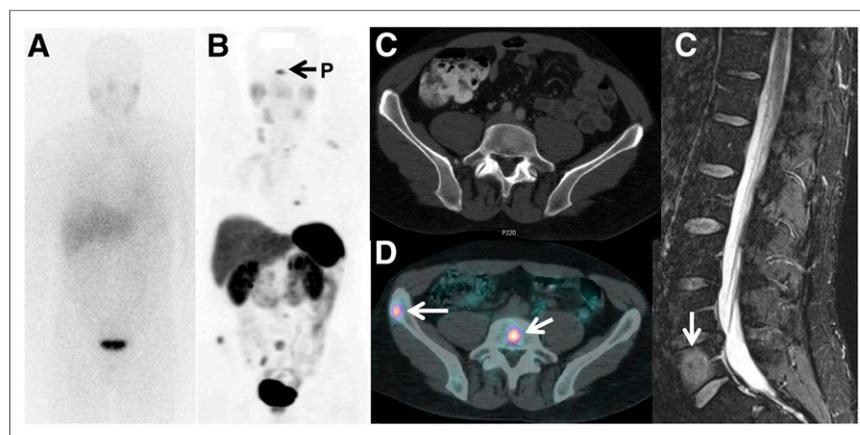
True-positive ^{68}Ga -DOTATATE PET/CT with false-negative ^{111}In -pentetreotide SPECT/CT. Anterior planar (A) image from ^{111}In -pentetreotide SPECT/CT scan was negative for residual tumor. Anterior 3-dimensional maximum-intensity-projection view (B) and fused PET/CT (D) with skeletal metastatic foci prospectively missed on contrast-enhanced CT (C), verified with MRI (selected short- τ inversion recovery image, (E)). Patient was referred for PRRT, which would have been denied based on false-negative ^{111}In -pentetreotide scan. Arrow indicates normal pituitary uptake (P).
